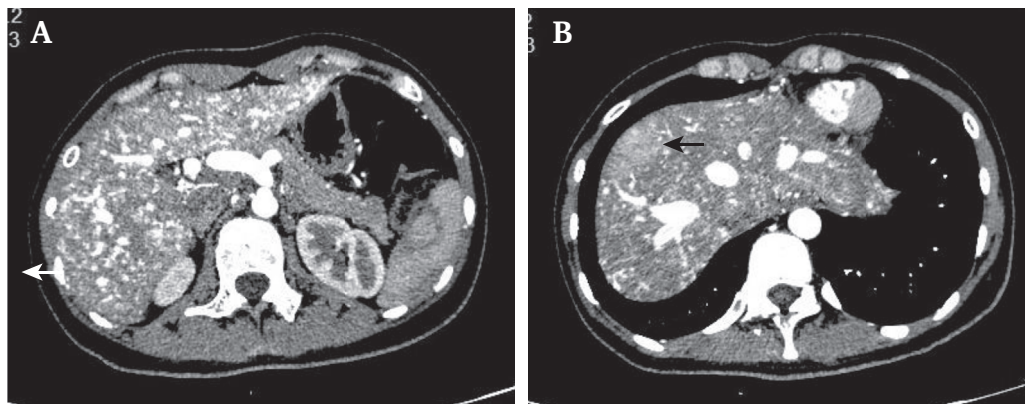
(A) Computed tomography (CT) showed a dilated coeliac trunk and common hepatic artery. (B) Contrast CT showed hyperplastic nodules (black arrow) and hepatic vein during the arterial phase, indicating the existence of hepatic arteriovenous fistulae.
